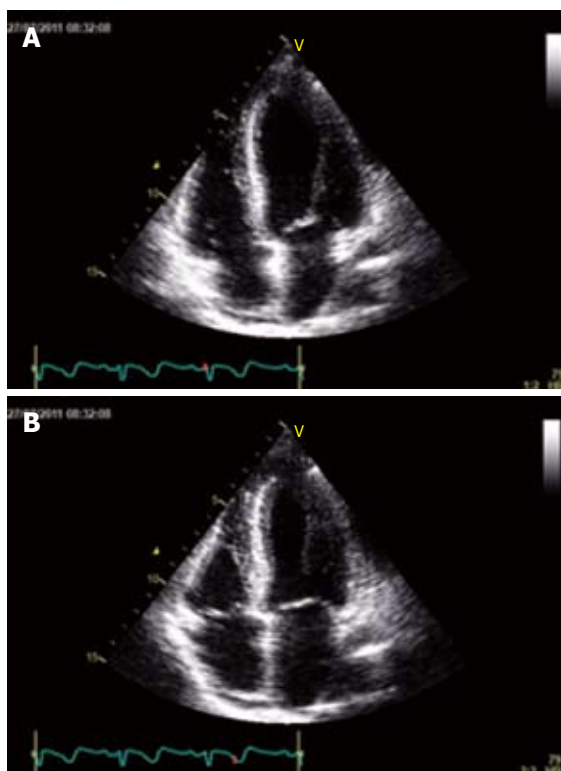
Echocardiography performed 3 wk later showed complete normalization of left ventricular function and resolution of contractility abnormalities, at the end of diastole (A) and at the end of systole (B).
